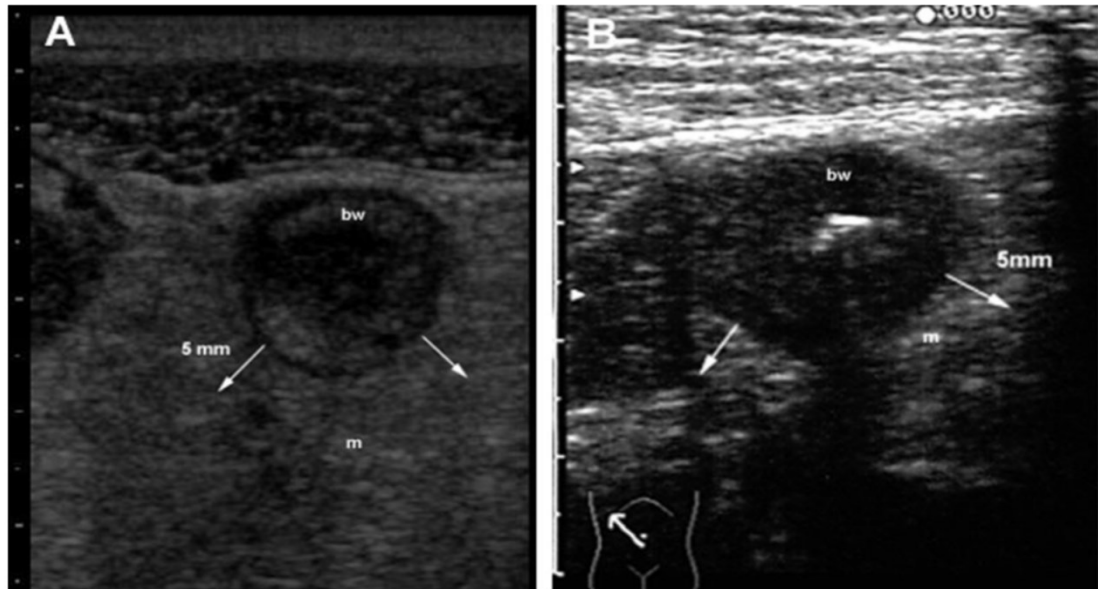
Ultrasonographic images of (A) severe mesenteric fat hypertrophy (m) assessed as a hyperechoic halo surrounding bowel wall (bw) in transverse section, and (B) mild mesenteric fat hypertrophy (m) in CD patients (Maconi et al., 2008).
